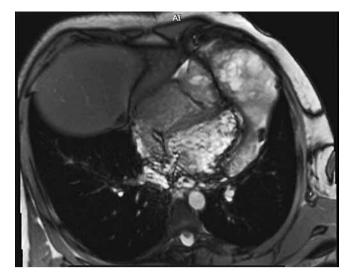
Cardiac tumor detected on a heart MRI in patient U., 17 years old
